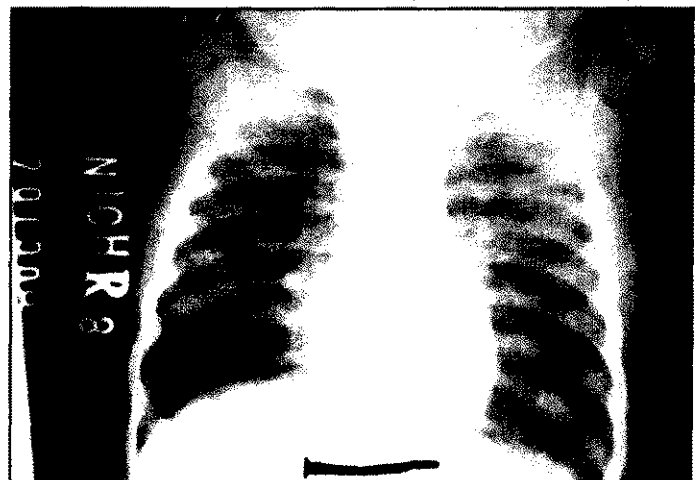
X-ray showing nail in neck and upper chest region.
